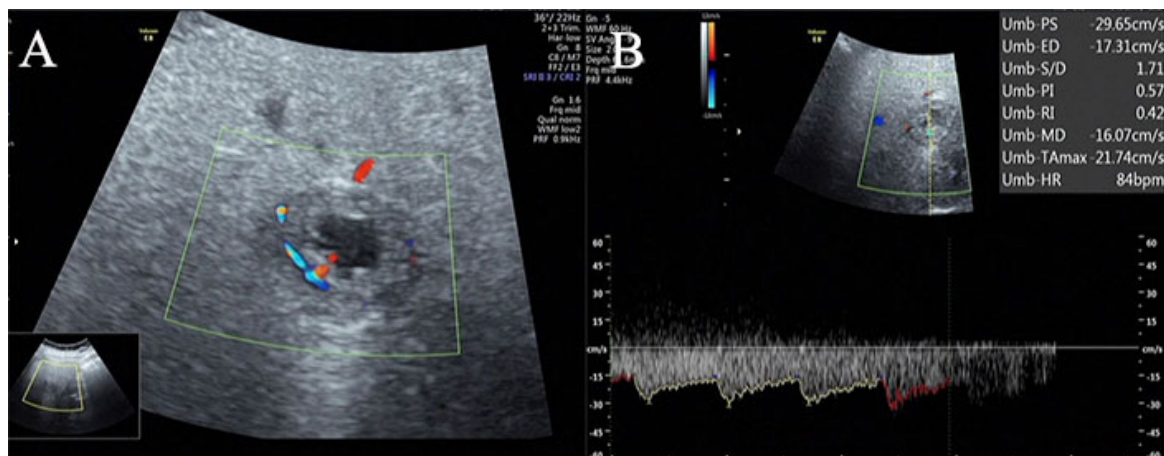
Abdominal ultrasonography scan showing a nodule with a hyperechoic ring and cystic center in the right lobe of the liver, and strip blood flow signals were detected at the edge of the nodule. (A) Doppler examination of the blood flow revealing an arterial spectrum, RI: 0.42. (B) Except for the nodule, an echo of other regions of the liver were normal.
